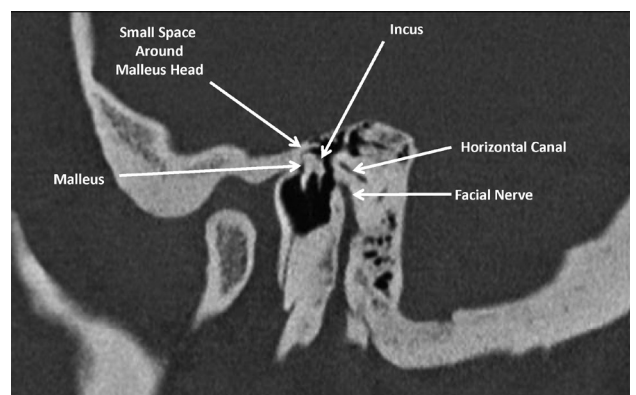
The sagittal CT image of the right temporal bone at the level of the malleus and incus indicated a small space between the malleus head and the epitympanic (attic) wall.
